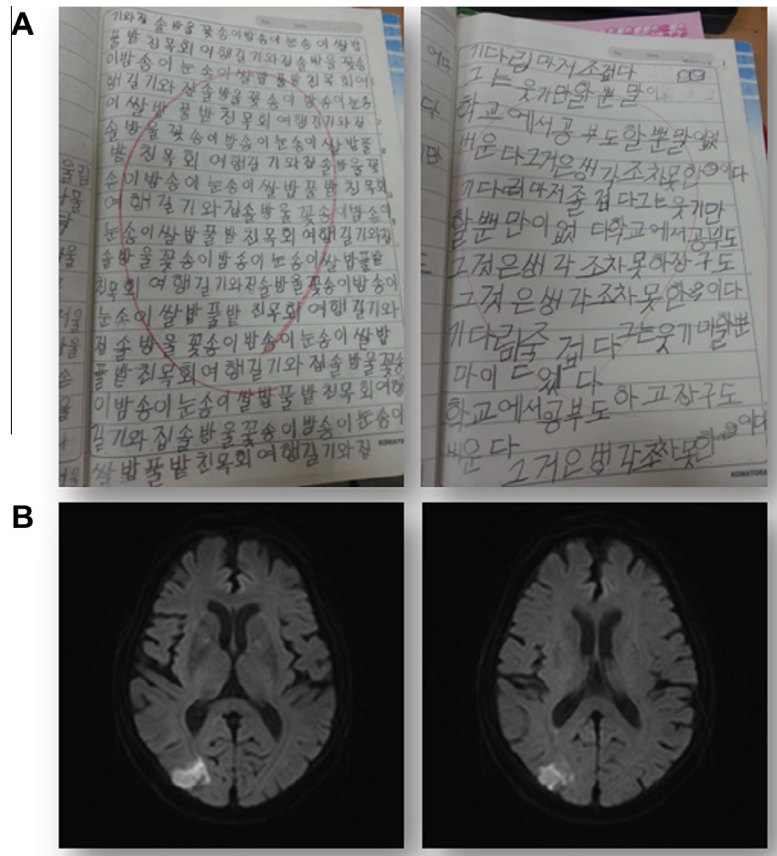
(A) Hangul writing before (left) and after (right) infarct. The patient used the phoneme-to-grapheme conversion and wrote the targets as they sound. Visual errors as well as untidiness characterized her post-infarction writing style. (B) Axial diffusion-weighted brain MRI showed an acute infarct in the right angular gyrus.
